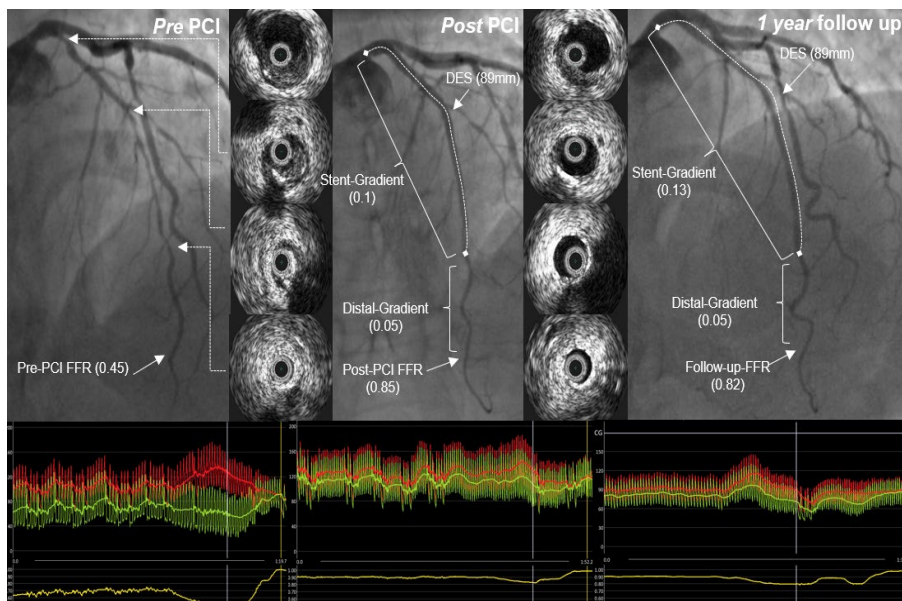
An example case from the IVUS-optimized PCI group. The figure displays the pre- and post-PCI angiographic images of a left anterior descending artery, as well as the corresponding intravascular ultrasound pictures and fractional flow reserve (FFR) curves (below). One-year follow-up angiographic images are also presented. The same FFR measurement methods were used in the FFR-optimized PCI group.
